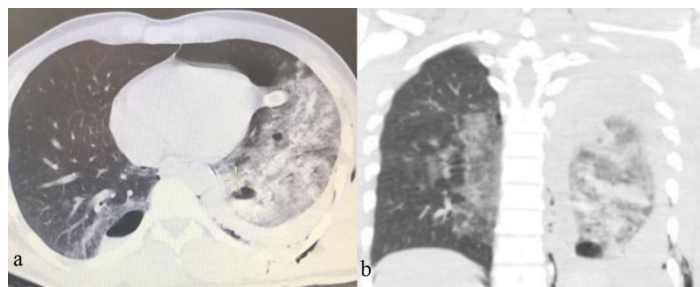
a-b: Computed tomography of the thorax revealed subcutaneous emphysema, multiple rib fractures, left hemopneumothorax, contusions and bilateral cavitory lesions (axial and coronal view).
